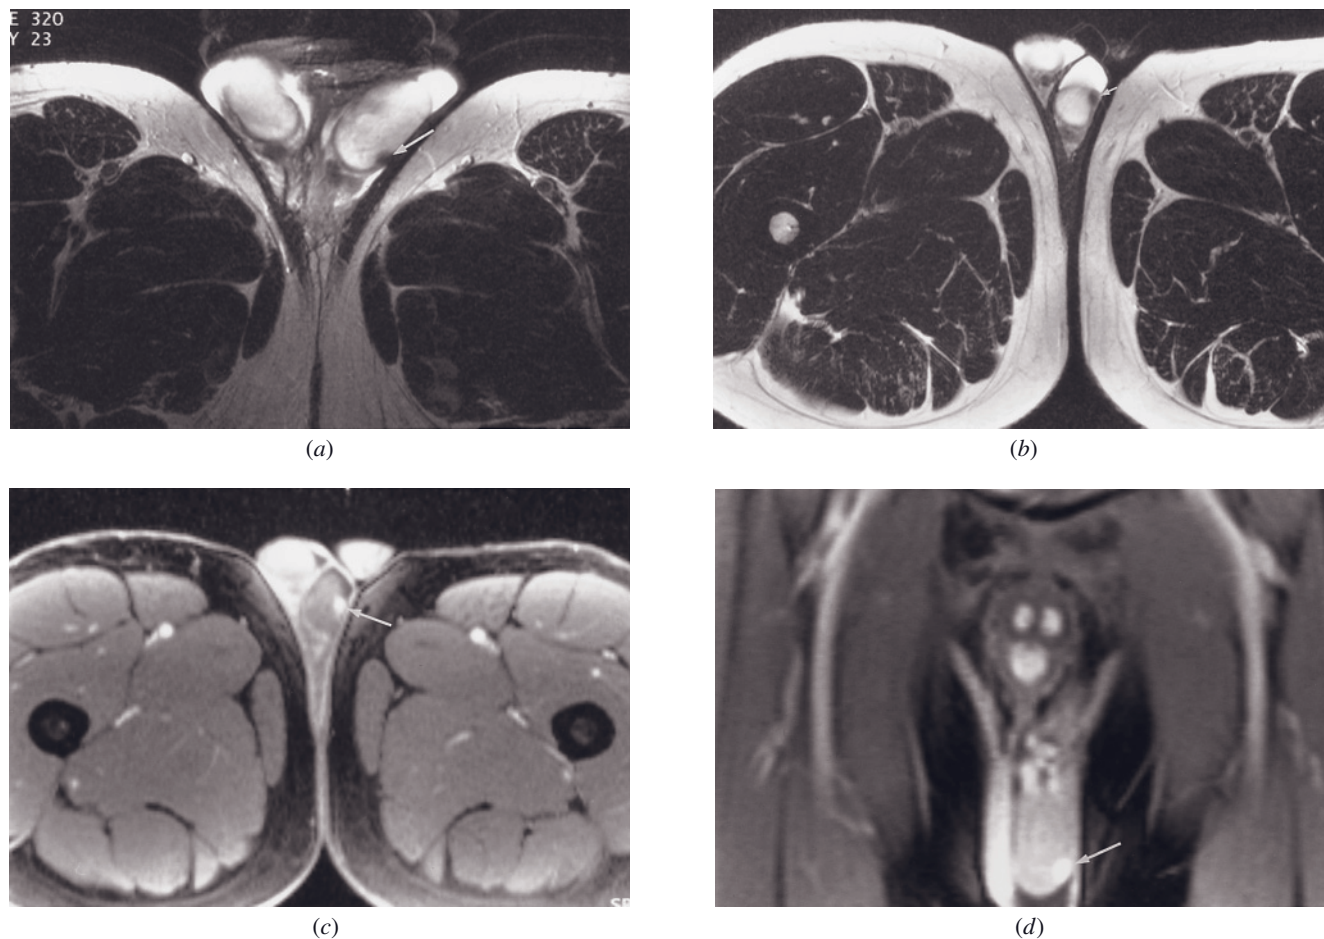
Adenomatoid neoplasm. Transverse phased-array body coil T2-weighted ETSE (*a*), transverse circular surface coil T2-weighted ETSE (*b*), transverse phased-array body coil T1-weighted immediate postgadolinium fat-suppressed gradient-echo (*c*), and coronal phased-array coil T1-weighted immediate postgadolinium fat-suppressed gradient-echo (*d*) images. The tumor is hypointense relative to the normal surrounding testis on T2-weighted imaging (arrows, *a*, *b*). After the administration of gadolinium, there is immediate increased enhancement of the tumor relative to the surrounding testis (arrows, *c*, *d*). Note that the higher signal-to-noise ratio of the circular surface coil permits higher spatial resolution imaging (*b*) compared to the phased-array body coil (*a*). This is useful for imaging superficial structures such as the testicles.
